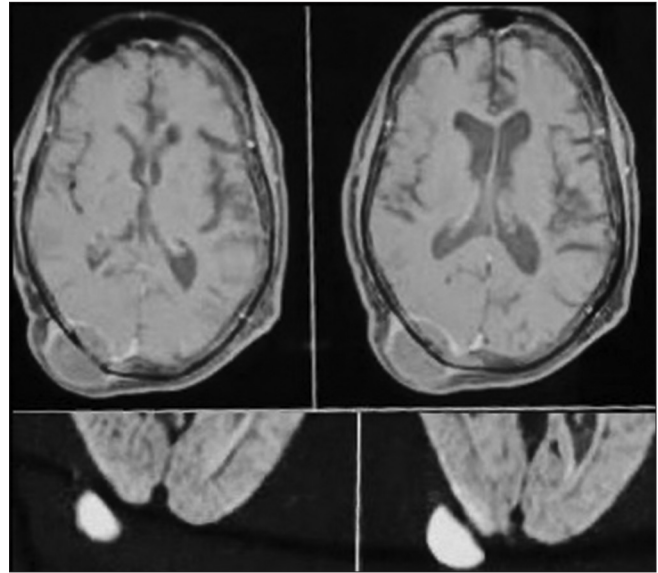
(Patient 2) Contrast T1W magnetic resonance imaging showing central necrotic pus with peripheral enhancement on either side of the right occipital bone; restriction noted in diffusion-weighted images.
